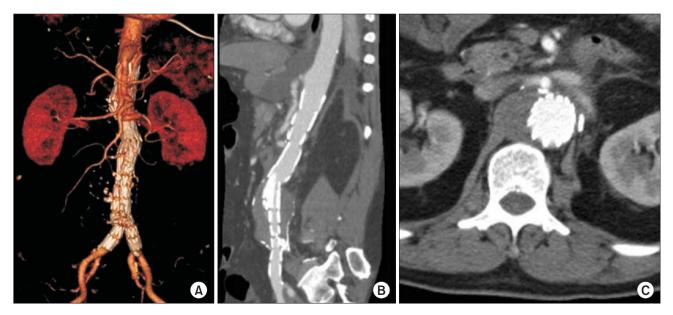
Follow-up 6 month computed tomography image shows a patent graft (A). The fusiform aneurysm (B) and the saccular aneurysm (C) are shown.
